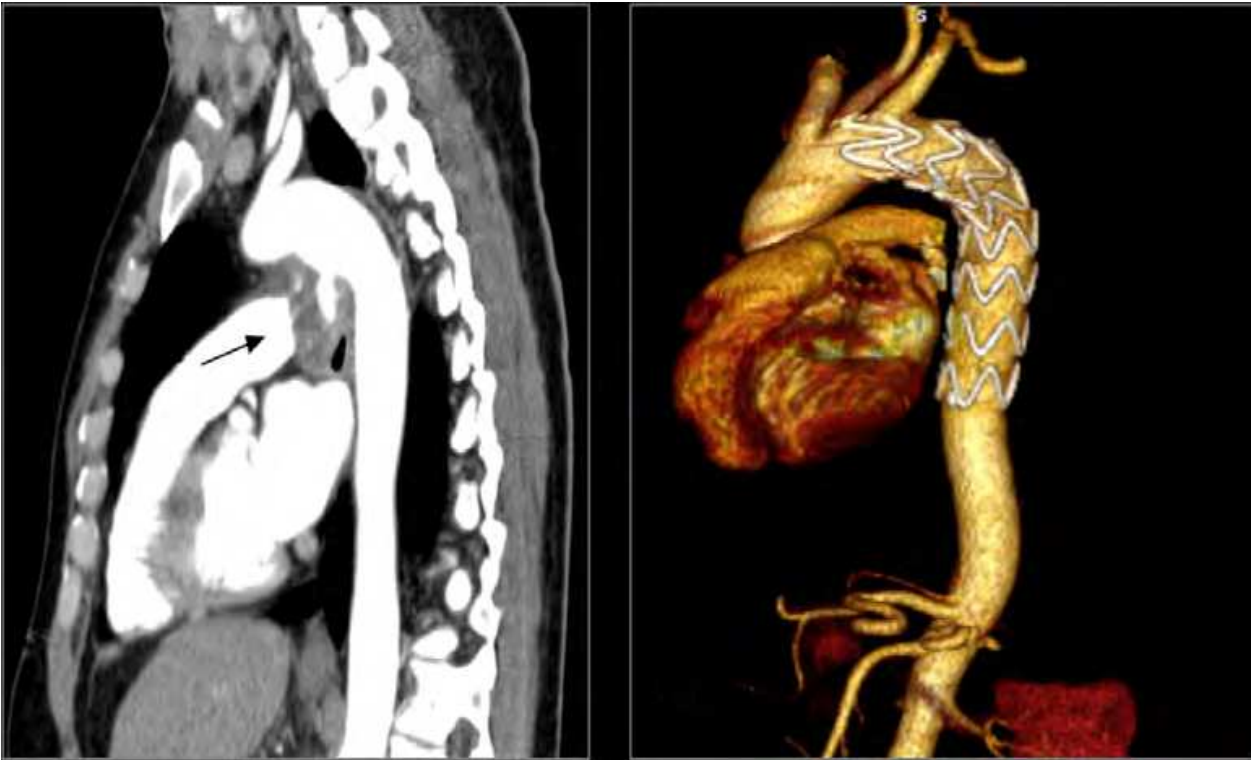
Case 17. Left: Chest computed tomography scan showing a mycotic pseudoaneurysm (arrow) in the descending thoracic aorta. Right: Computed tomography scan demonstrating correct position of the stent graft.
